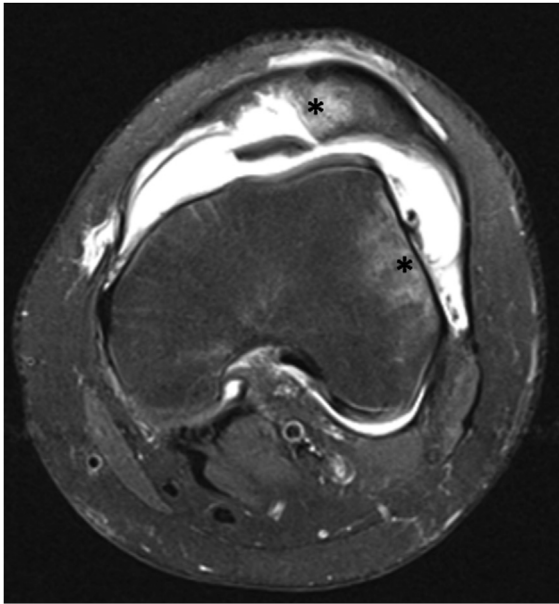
Axial magnetic resonance image depicting edema over the medial patella and lateral femoral condyle (asterisks) and effusion.
